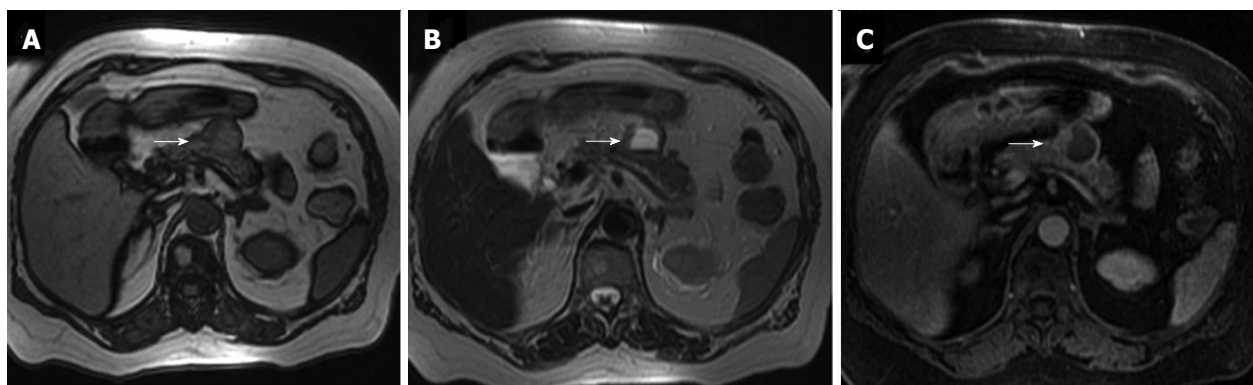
Same patient shown in figure 14. Magnetic resonance axial gradient T1 out-of-phase image (A) and T1 fat-suppressed sequence (C) show a hypointense signal in the liquid component of the lesion whereas it reveals a hyperintense signal in the T2-weighted sequence (B) (arrows).
